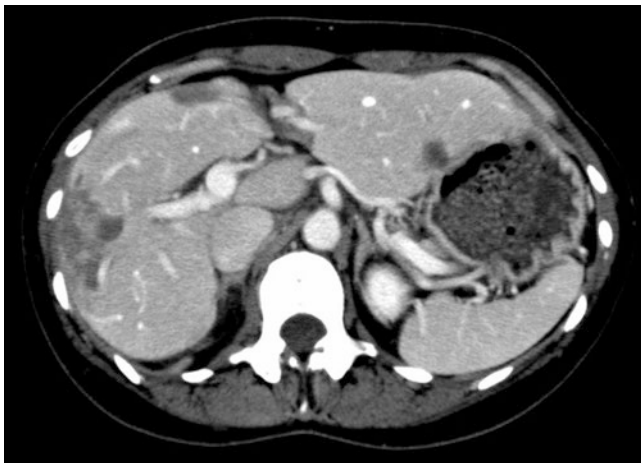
Epithelioid hemangioendothelioma; CT images. CECT shows multiple low-density areas in the early phase, and these are localized mainly in the periphery of the liver. (Courtesy of Professor H Haga)
